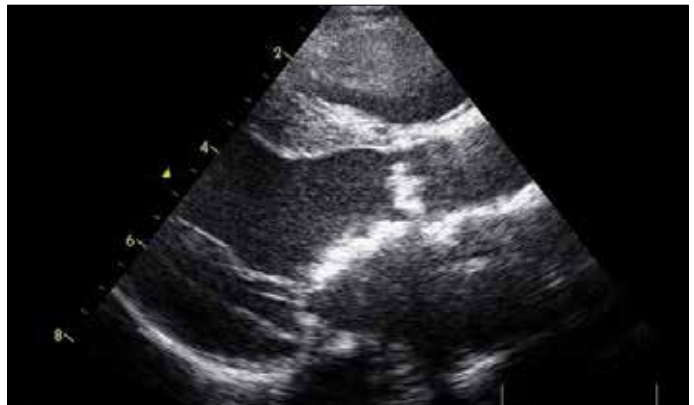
In the parasternal long axis cross-section, anterior mitral valve leaflet, the aortic annulus, and the endocardium layer were thick and hyperechogenic
